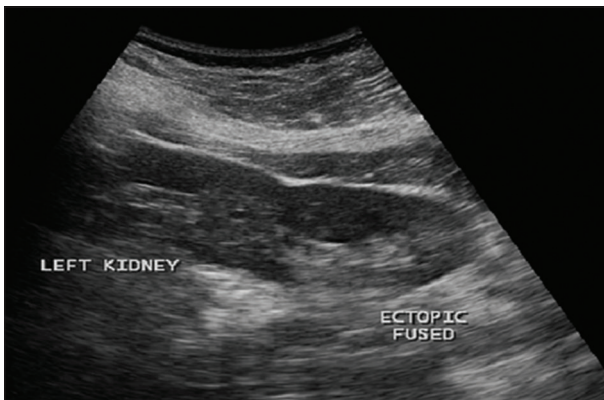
Ultrasonography abdomen and pelvis showing crossed fused ectopic left kidney
